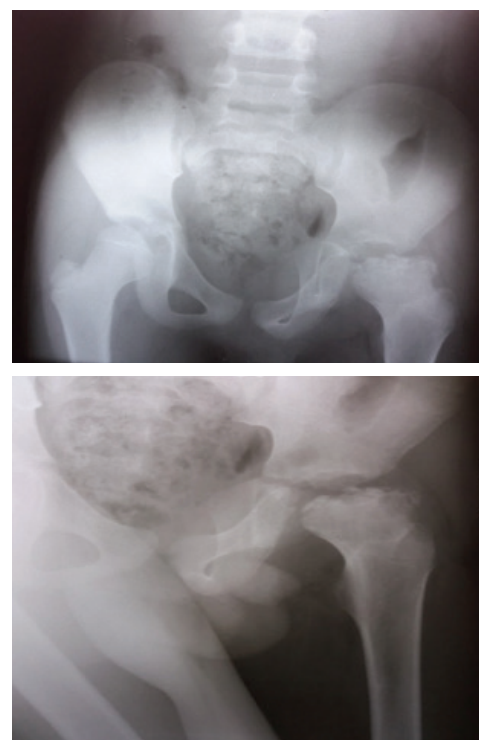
Pelvic x-ray with an anteroposterior view.
